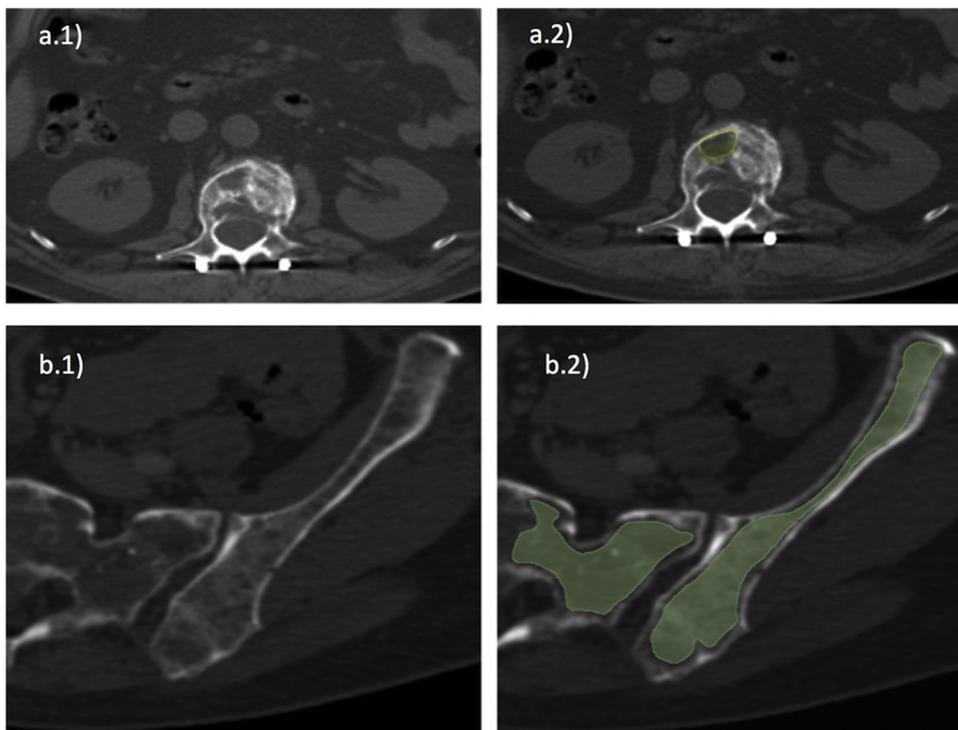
Examples of focal and diffuse bone patterns on CT.
